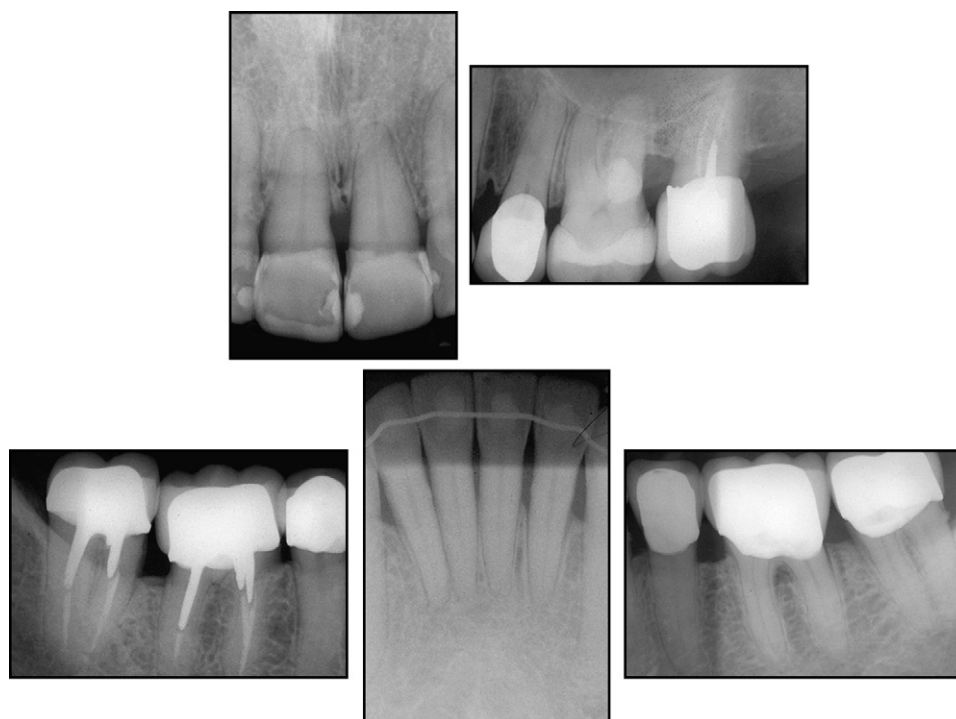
Follow-up periapical radiographs at 17 months.
